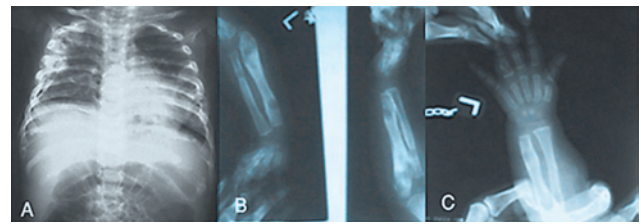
Chest X-rays (A) and left forearm X-rays (B, C) revealed multiple lytic lesions in the ribs and the forearm.
